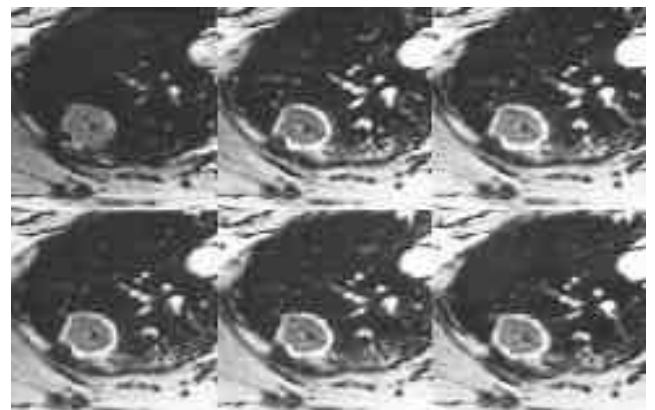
39-year-old man with tuberculoma (patient 18). Serial MR images show peripheral rim-like enhancement of SPN. The nodule has small cavity in the center. The p%SI is reached in 2 minutes (Top right) and forms a plateau thereafter.
